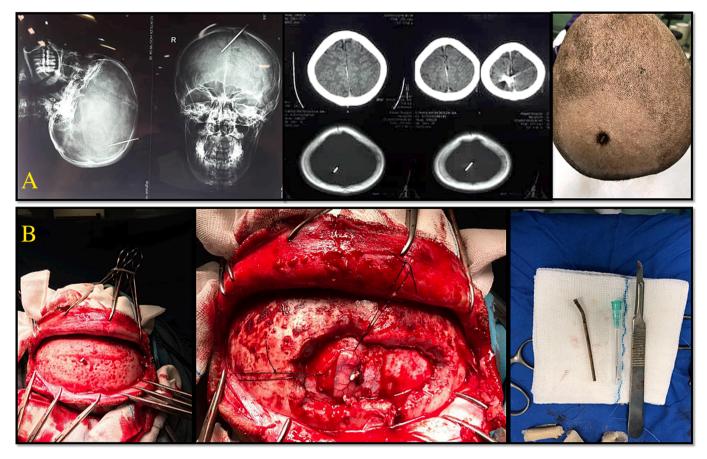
(A) The plain X-ray showed an oblique nail penetrated from the left lobe to the right parietal lobe. Computed tomography did not show intracranial bleeding. The nail entrance was visible at the left parietal scalp. (B) The nail was visible without bleeding after scalp incision and craniotomy. A six-centimeter nail was entirely removed by surgery.
